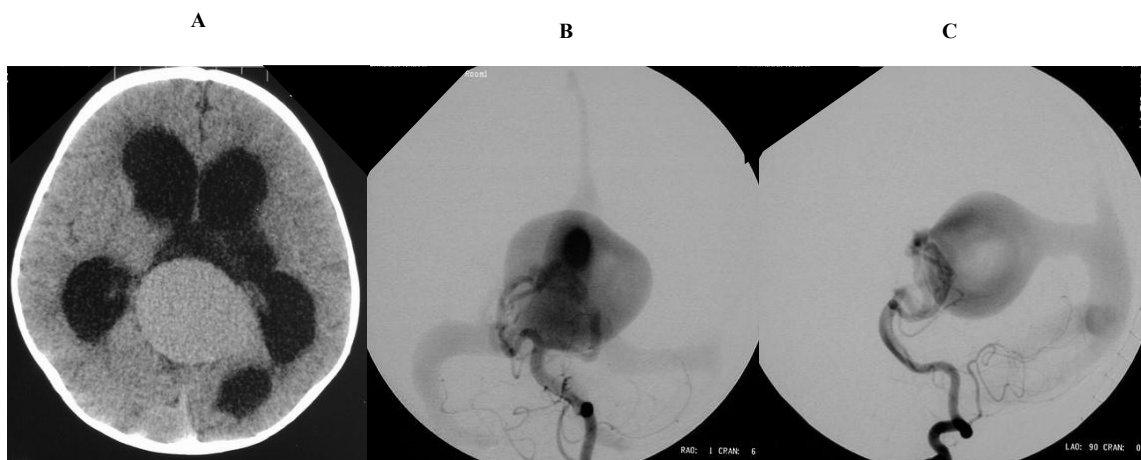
Mural type VGAM of a 6 month-old girl with macrocephaly. A: Non contrast CT showing enlarged vein of Galen and ventriculomegaly. B, C,: PA (B) and lateral (C) views of the left vertebral angiogram showing mural type VGAM supplied bilateral posterior choroidal arteries and drained by the embryonic falcine sinus.
